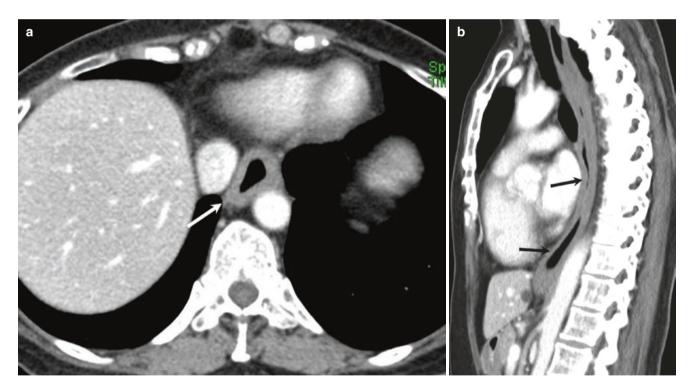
Diffuse esophageal spasm. (a, b) Axial and sagittal CT images show long-segment diffuse circumferential esophageal thickening (arrows) involving the mid and lower esophagus with more severe
